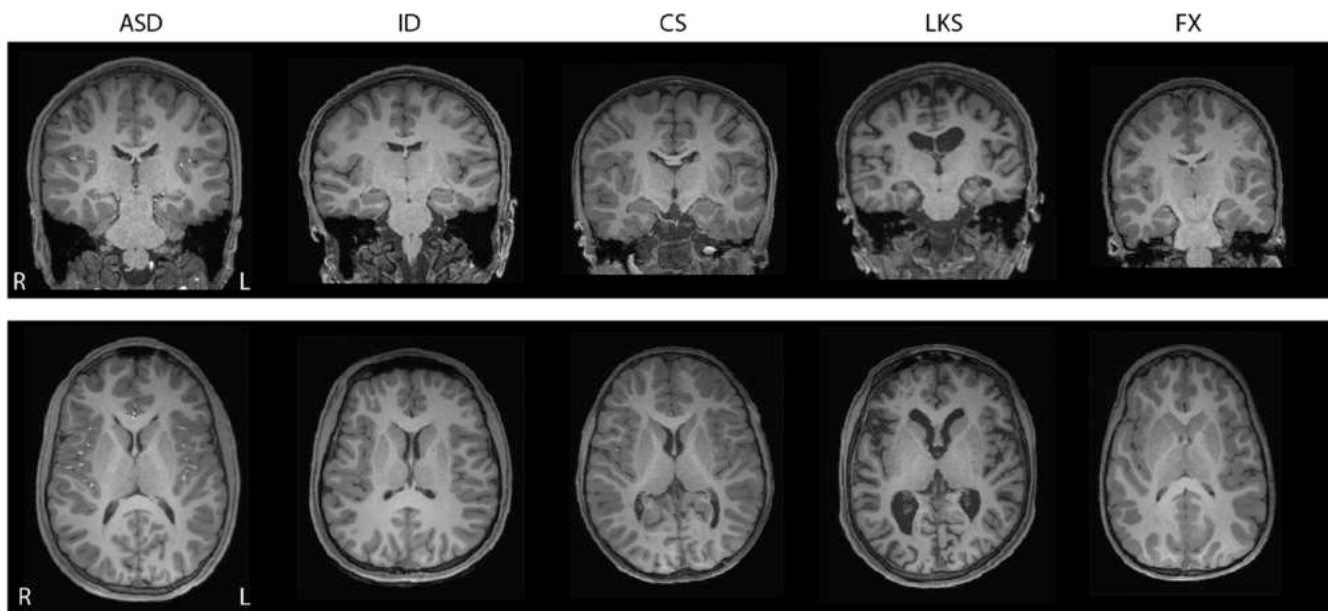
T1-weighted structural images from the five cases in coronal and axial planes. Clinical radiological examination revealed no abnormalities in the ASD, ID and FX cases. In the CS case dysgenesis of the corpus callosum and a megacisterna magna consisting in an enlargement of the CSF-filled subarachnoid space in the posterior cranial fossa was detected. The LKS case showed enlargement of the lateral ventricles, particularly on the left.
